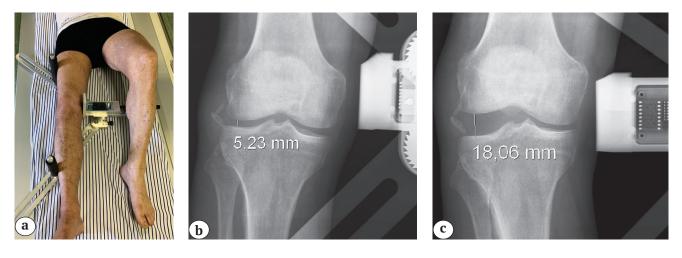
The functional knee X-ray in the patient with fibular collateral ligament injury: a — the appearance of the limb with a device for functional X-ray; b — the knee X-ray in frontal plane without load; c — the knee X-ray in frontal plane with a load in the patient with fibular collateral ligament complete rupture The functional X-ray examination provided the diagnosis of multidirectional knee instability, including lateral instability.
